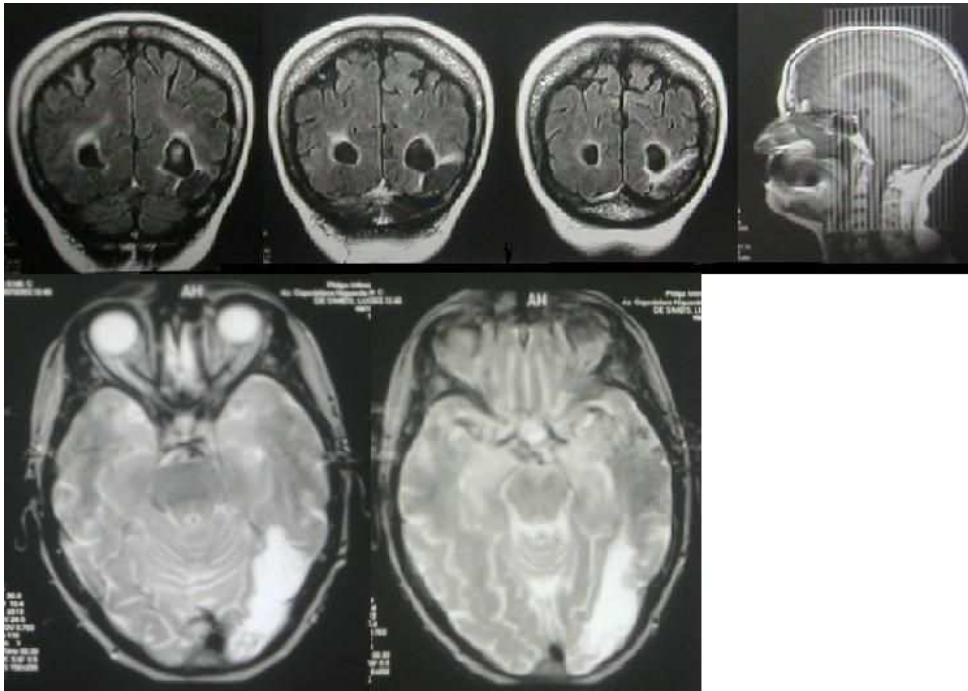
MRI scans of LDS. The coronal and axial sections show a lesion in the left occipito-temporal lobe which involves the occipito-temporal fusiform gyrus and include the occipito-temporal sulcus. The corpus callosum is intact.
